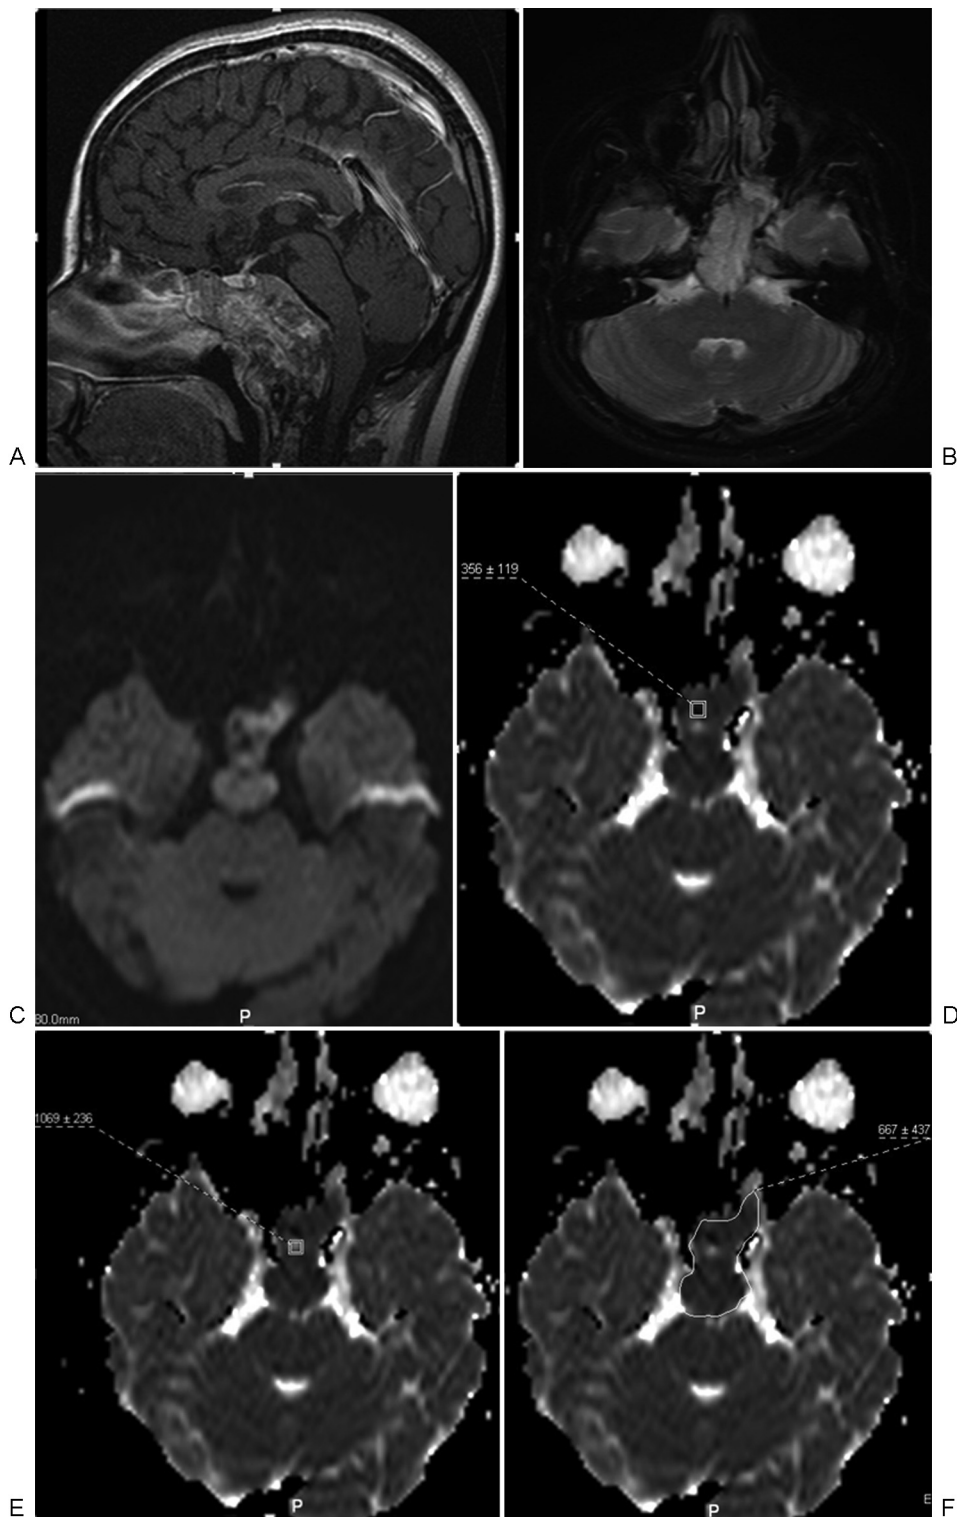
(A) Sagittal postcontrast T1-weighted (W) image, (B) T2W image, and (C) diffusion-weighted trace image show a mass that destroys the clivus. Apparent diffusion coefficient (ADC) measurements are obtained from three locations: (D) ADC_1 , (E) ADC_2 , and (F) $ADC_{\text{entire tumor}}$. ADC_1 , ADC value of the lowest signal of tumor observed in ADC map; ADC_2 , ADC value of the highest signal of tumor observed in ADC map; $ADC_{\text{entire tumor}}$, ADC value of the entire tumor volume.
